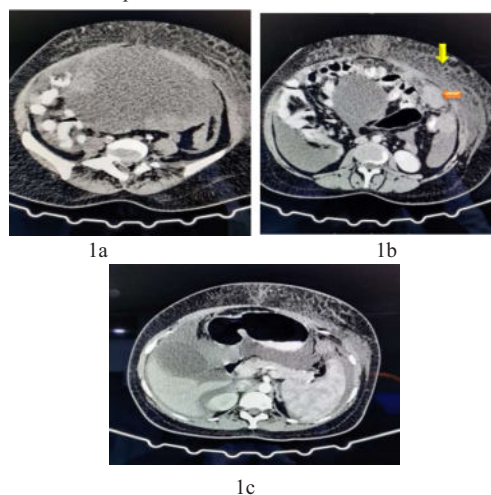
A 36-year-old female with abdominal pain and distension since 2 months. Contrast enhanced CT scan obtained for abdomen and pelvis which showed (on axial sections) large solid cystic lesion in the pelvis (1a), diffuse subcutaneous edema of the abdominal wall (yellow arrow) and metastatic peritoneal deposit (orange arrow) (1b) and nodular deposit along the gastrosplenic ligament (arrow) (1c).
